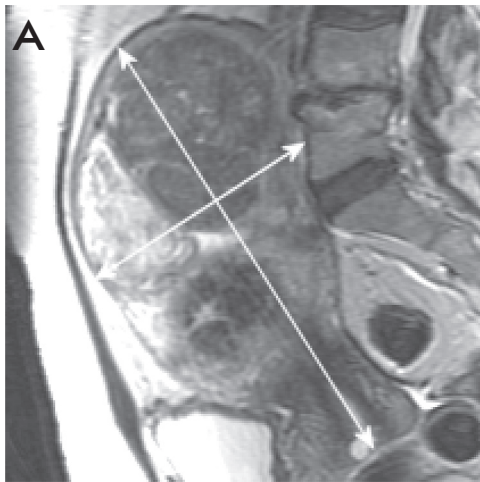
Sagittal T_2 -weighted MR image; uterus with 3 intramural fibroids: measurement of the largest longitudinal (long arrow) and anterior-posterior distance of the uterus.
